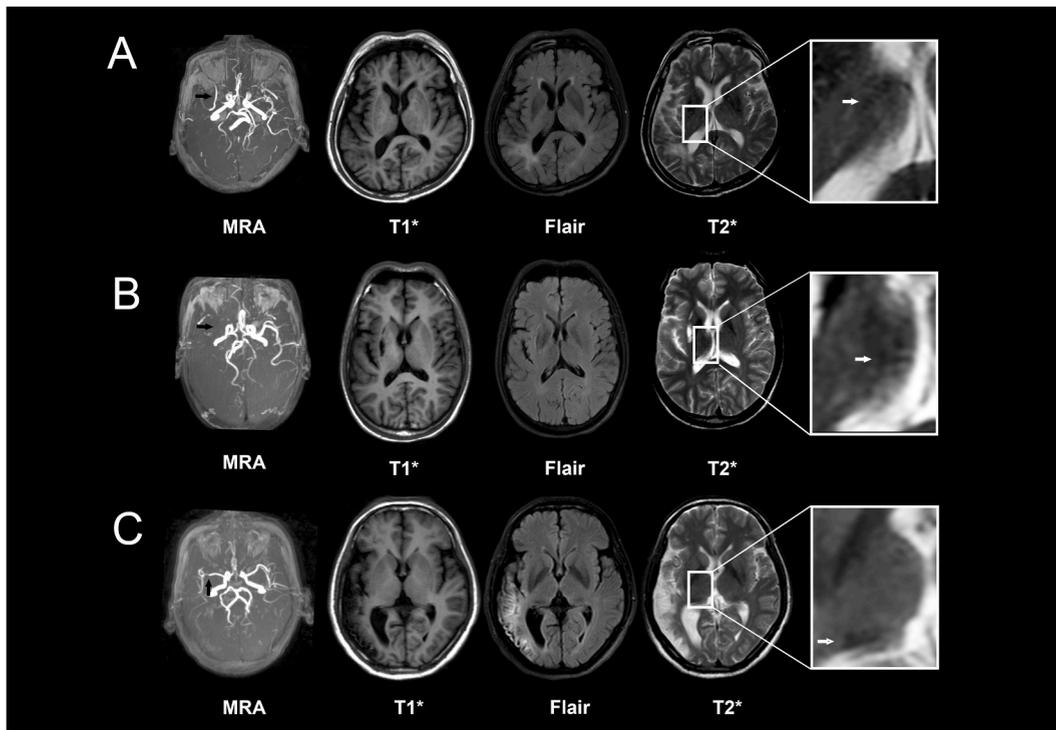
Exemplary MRI sequences of the ipsilateral thalamus after unilateral middle cerebral artery occlusion. The men aged 40 (A), 73 (B), and 49 (C) were diagnosed with chronic cerebral infarction caused by the occlusion of M1 or/and M2 of the MCA (black arrow), with no thalamus infarction on T1 and FLAIR sequences, but hypointensity (white arrow) in the ipsilateral thalamus on T2 sequences.
